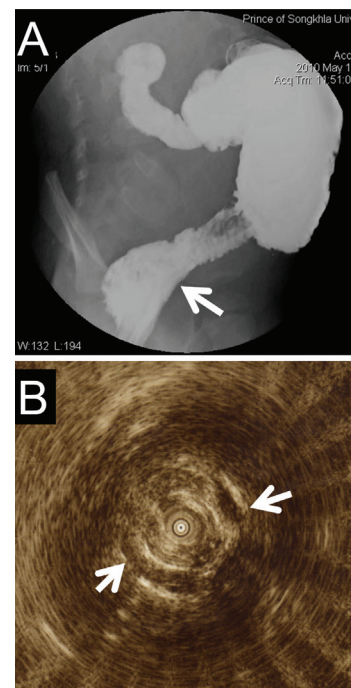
A) Barium enema study performed at 20th post-operative month showed normal size neorectum (arrow) with irregular mucosal lining indicating chronic inflammation. B) Endosonography performed at 6th post-operative month showed the neoanus lying within the sphincter complex (arrows)
